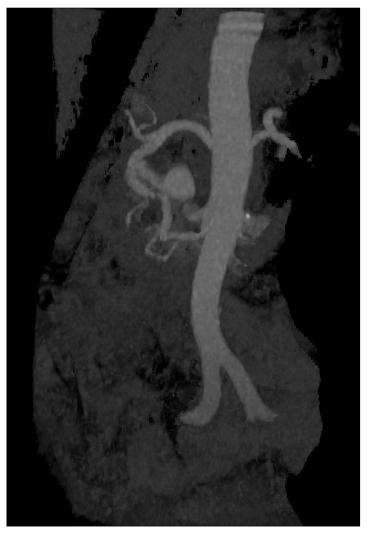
Postoperative computed tomography scan (threedimensional) showing residual filling of the right gastroepiploic artery.
